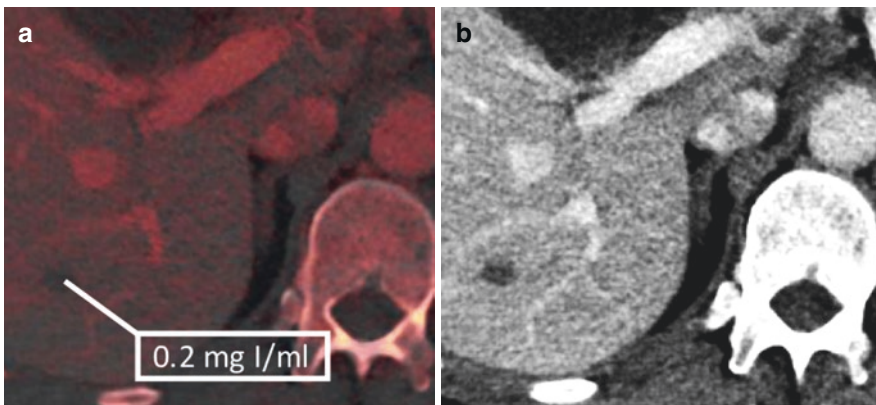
Iodine material attenuation map (a) shows absence of significant iodine uptake of a 0.9 cm hypoattenuating lesion on contrast-enhanced CT on portal venous phase (b) deemed indeterminate 68-year-old male
